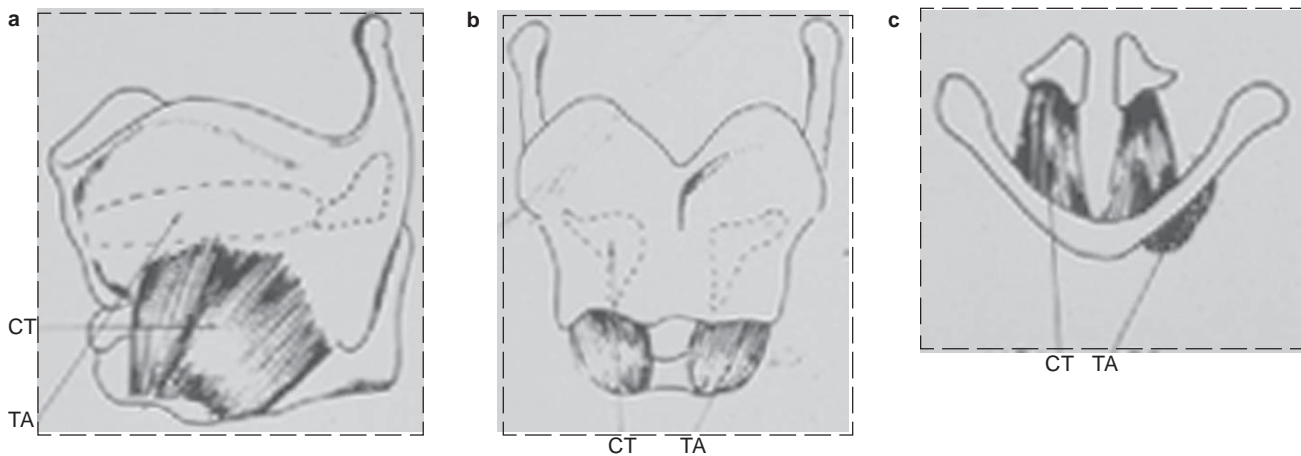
(a) Lateral, (b) anterior, and (c) superior projection of the larynx and EMG needle insertion sites. CT: Cricothyroid muscle. TA: Thyroarytenoid muscle. Reprinted with permission from Simpson D, Sternman D. Vocal Cord Paralysis: Clinical and Electrophysiologic Features. *Muscle Nerve.* 1993;16:953.
